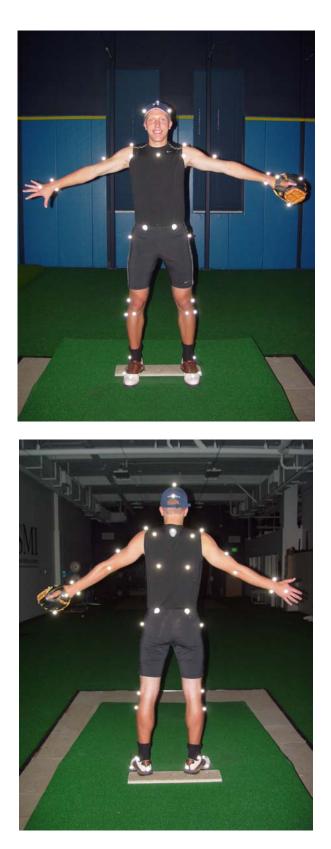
Combined ASMI and MRI reflective marker setup 25
